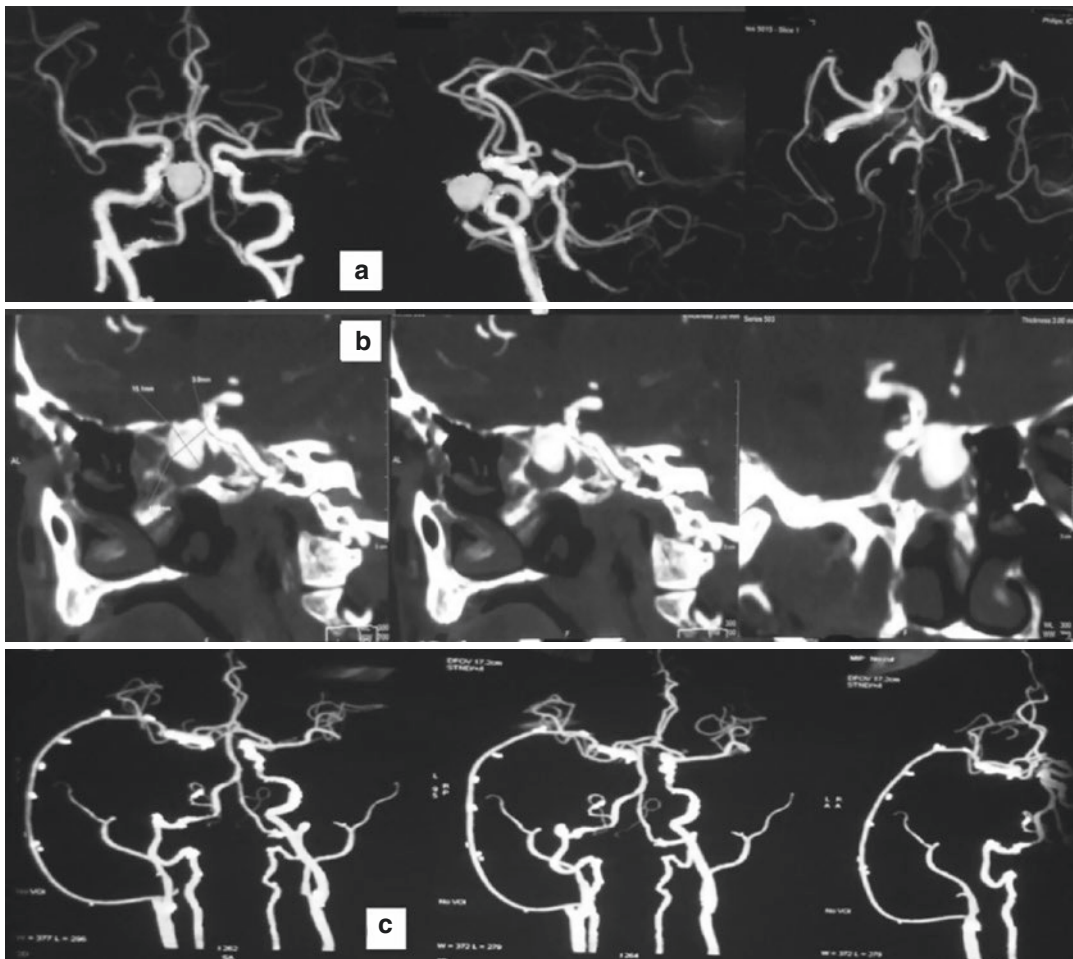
(a, b) Shows CTA showing the right petrous ICA pseudoaneurysm. (c) Shows postop CTA showing a right high flow (ECA-M2) bypass with radial artery graft (RAG), and the clipped aneurysm
